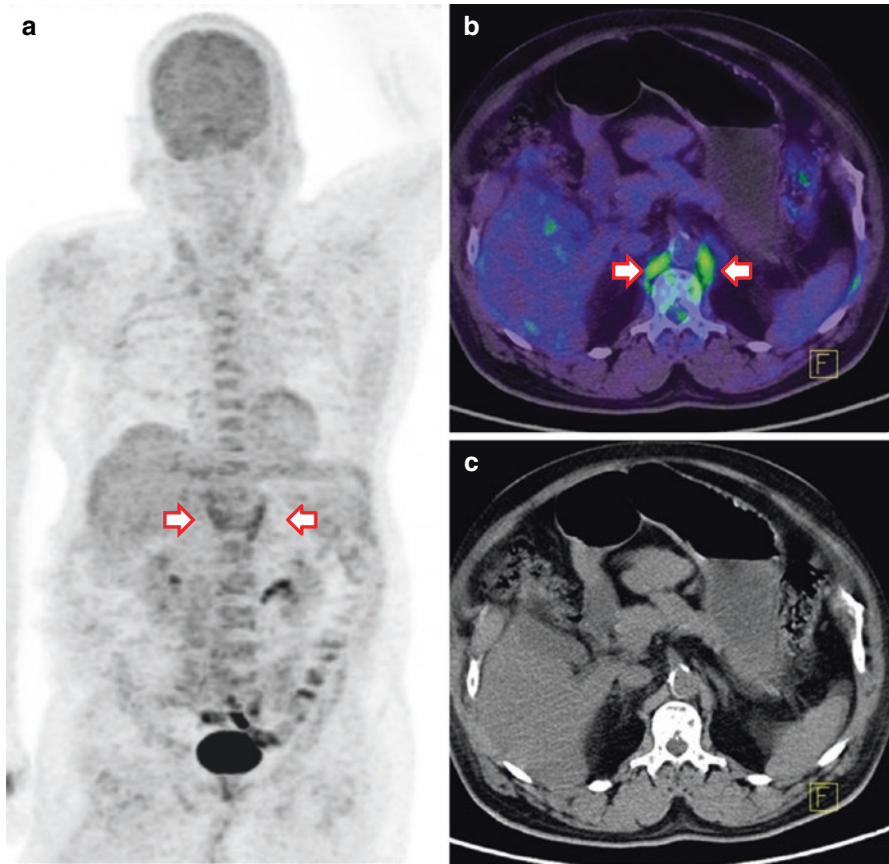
FDG uptake in bilateral diaphragmatic crura (a - MIP). Physiological nature of the uptake can be ascertained by the symmetrical nature of FDG uptake (b) and absence of any lesion in the CT part (c)
